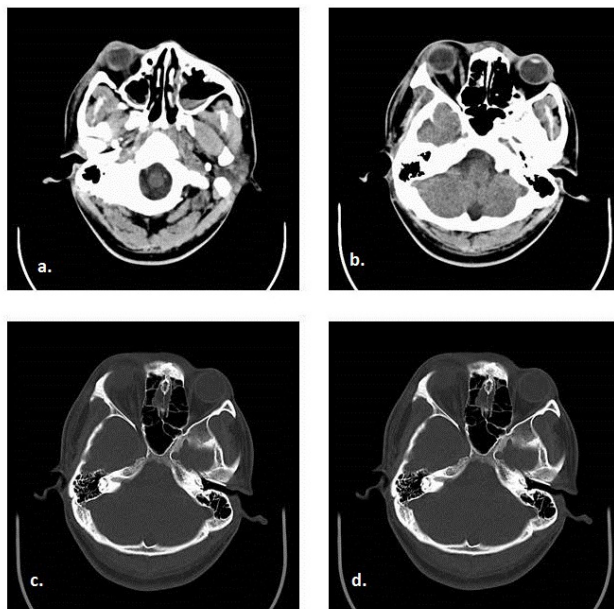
CT scan brain and orbit (axial view); a) and b) Mild Proptosis with mild scleral thickening, c) and d) Slight mucosal thickening of right ethmoid sinus with an intact medial orbital wall (lamina papyracea)
